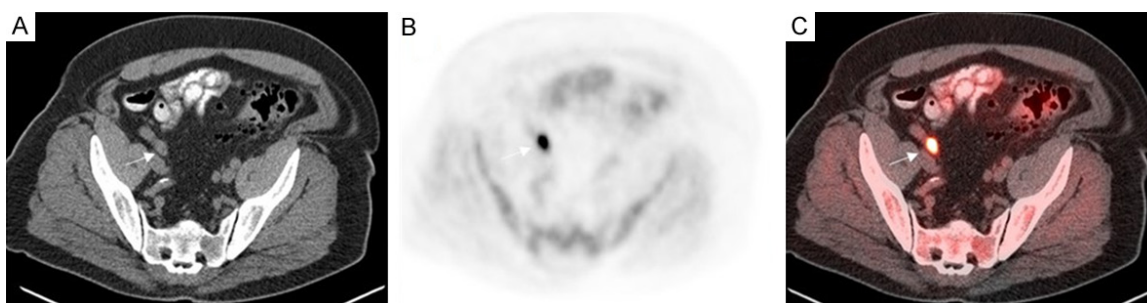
68-year-old male with Gleason 9 prostate cancer, status post primary radical prostatectomy, who presented with rising serum PSA. The serum PSA at the time of presentation was 0.29 ng/mL. Axial CT (A), axial ¹⁸F-Fluciclovine (B) and axial fused ¹⁸F-Fluciclovine PET/CT (C) images demonstrate radiotracer avid right pelvic lymph node, suggestive of nodal metastasis.
